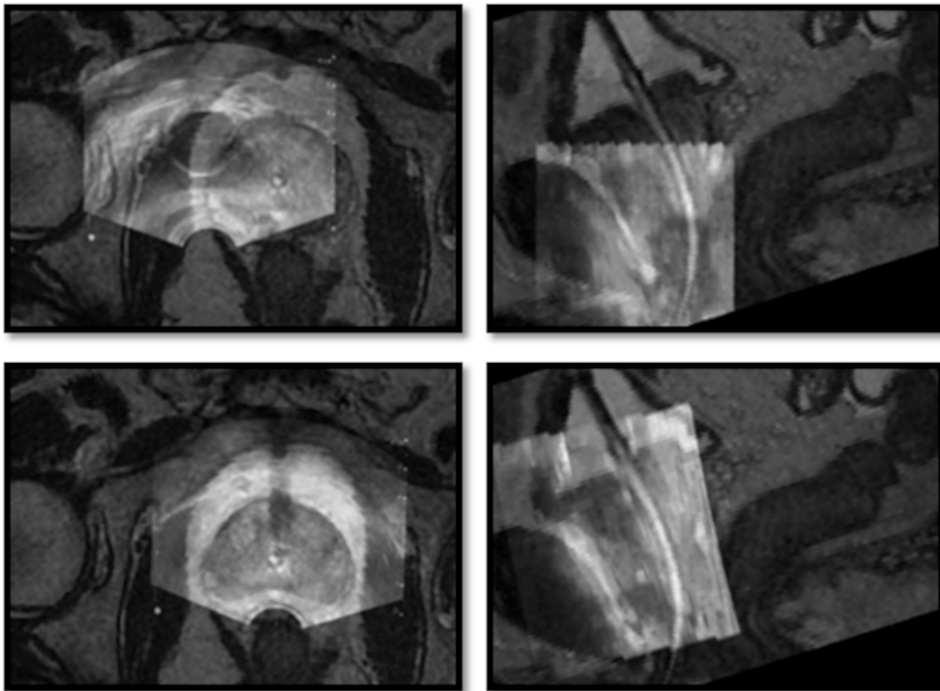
Two different views of the TRUS-0 image overlaid on top of the MRI, both images acquired prior to needle insertion, before (*top row*) and after (*bottom row*) rigid registration was performed for the PAT1 image data.
